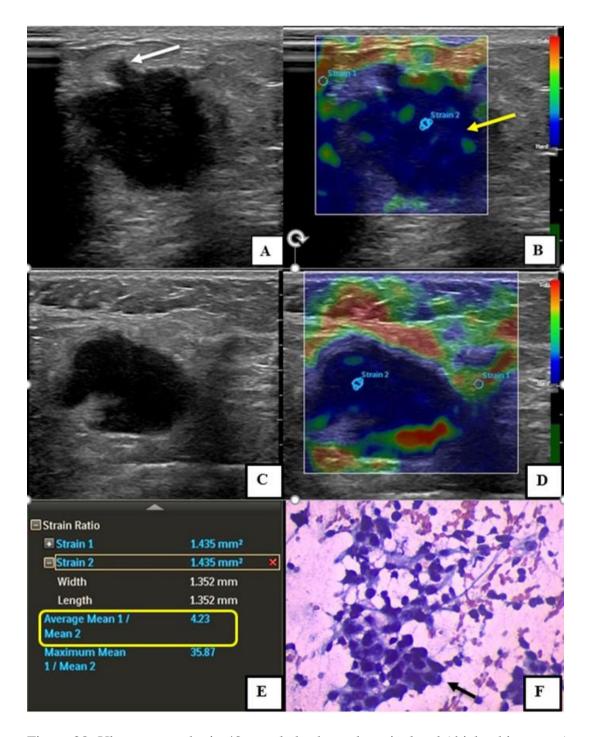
Ultrasonography in 40-year lady showed a spiculated (thick white arrow), hypoechoic solid lesion (Fig A) with multiple right axillary lymph nodes enlargement and loss of fatty hila (Fig C) suggestive of BIRADS 5. On elastography, (Fig B & E) the lesion (thick yellow arrow) and lymph nodes showed uniform blue colour pattern suggestive of malignancy (score 2). Mean strain ratio was 4.23 (Fig E; yellow box) and 4.03 for mass and axillary lymph node respectively. FNAC showed ductal epithelial cells with high nuclear cytoplasmic ratio suggestive of infiltrating ductal carcinoma (Fig F).
